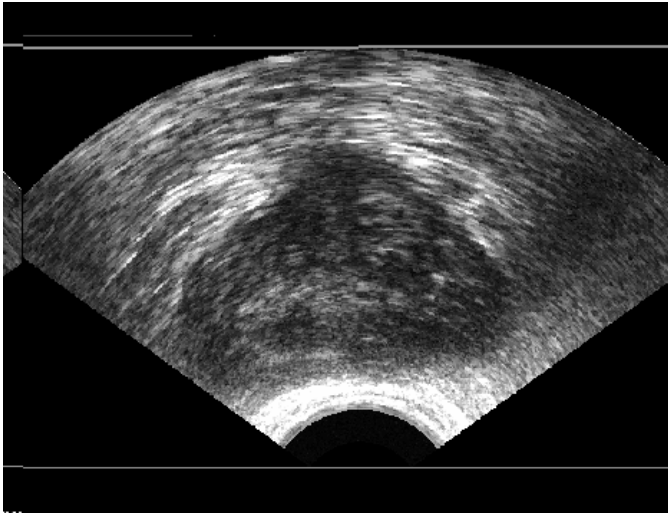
Original Ultrasound Image of the Prostate.
